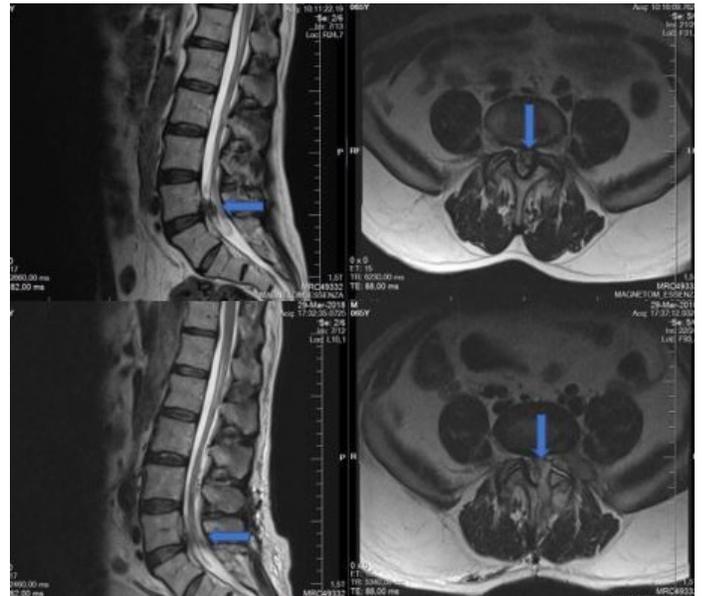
Preoperative sagittal and axial lumbar MRI images (upper figures) and early postoperative sagittal and axial lumbar MRI images (lower figures) of a 65-year-old male patient. Appearance of extruded disc fragment before and after LMD (blue arrows)
